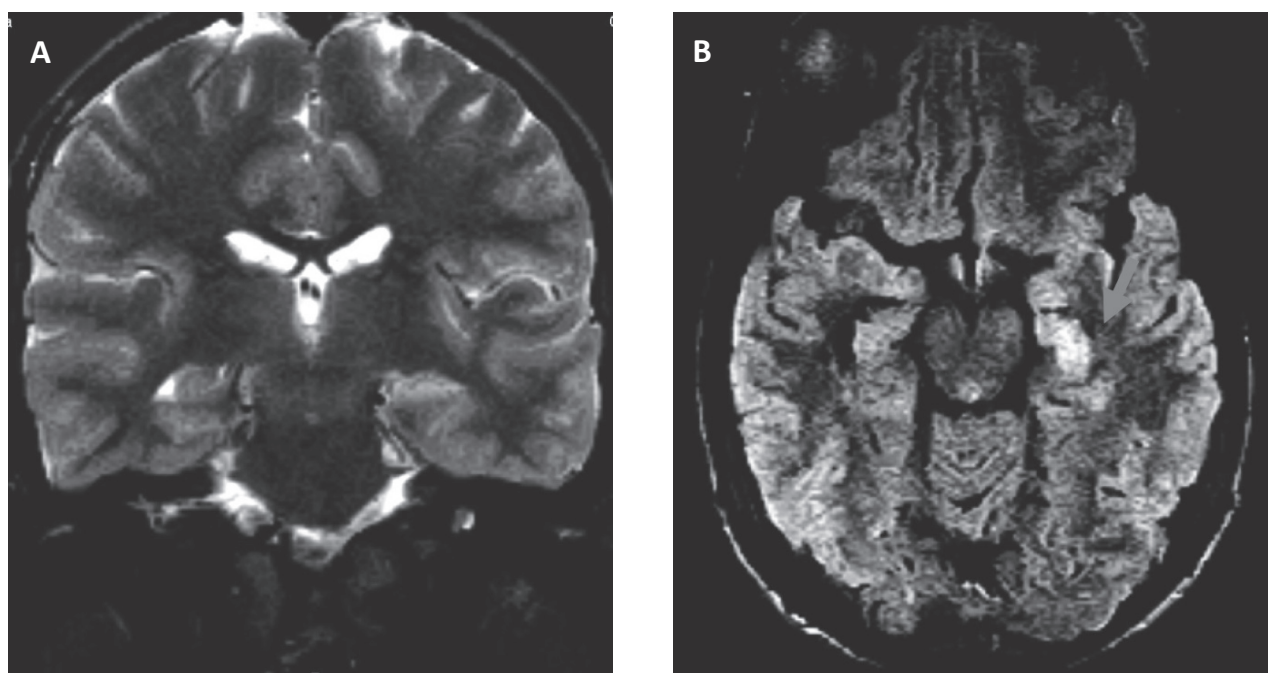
Coronal T2 (A) and axial FLAIR weighted (B) magnetic resonance imaging showing the hyperintensity of the left hippocampus with a decrease in size, which is an aspect that, considering the clinical context, is indicative of left mesial temporal sclerosis.
